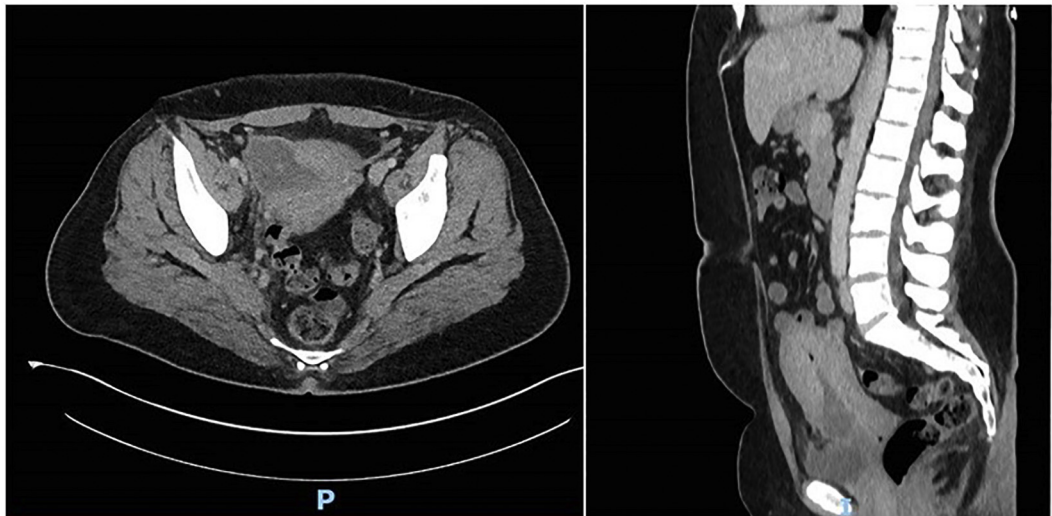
CT scan images showing a CSD. There is some fluid attenuation centrally. This measures over 4 cm and extends towards the surface of the uterus.
